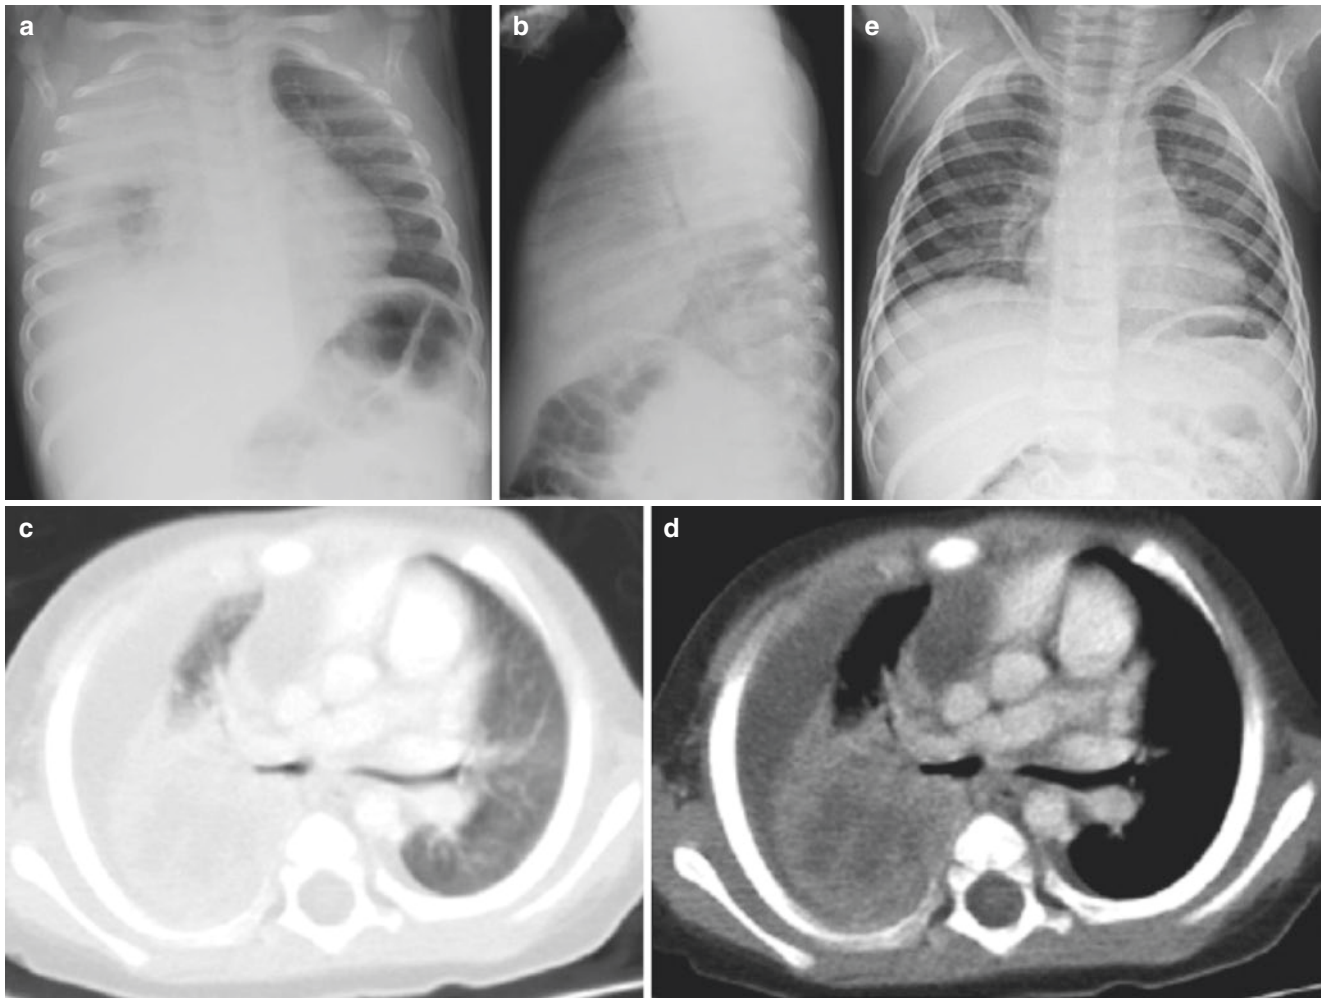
A 9-month-old girl who presented with fever, cough, and respiratory distress. (a) PA chest radiograph shows a consolidation of the majority of the right lung and possible loculated pleural effusion. (b) The lateral chest radiograph confirms significant opacification. Neither suggests cavitation. (c) Axial lung window CT image suggests irregular areas of non-enhancing tissue, representing necrotic areas and surrounded by enhancing lung parenchyma. The necrotic areas have not
